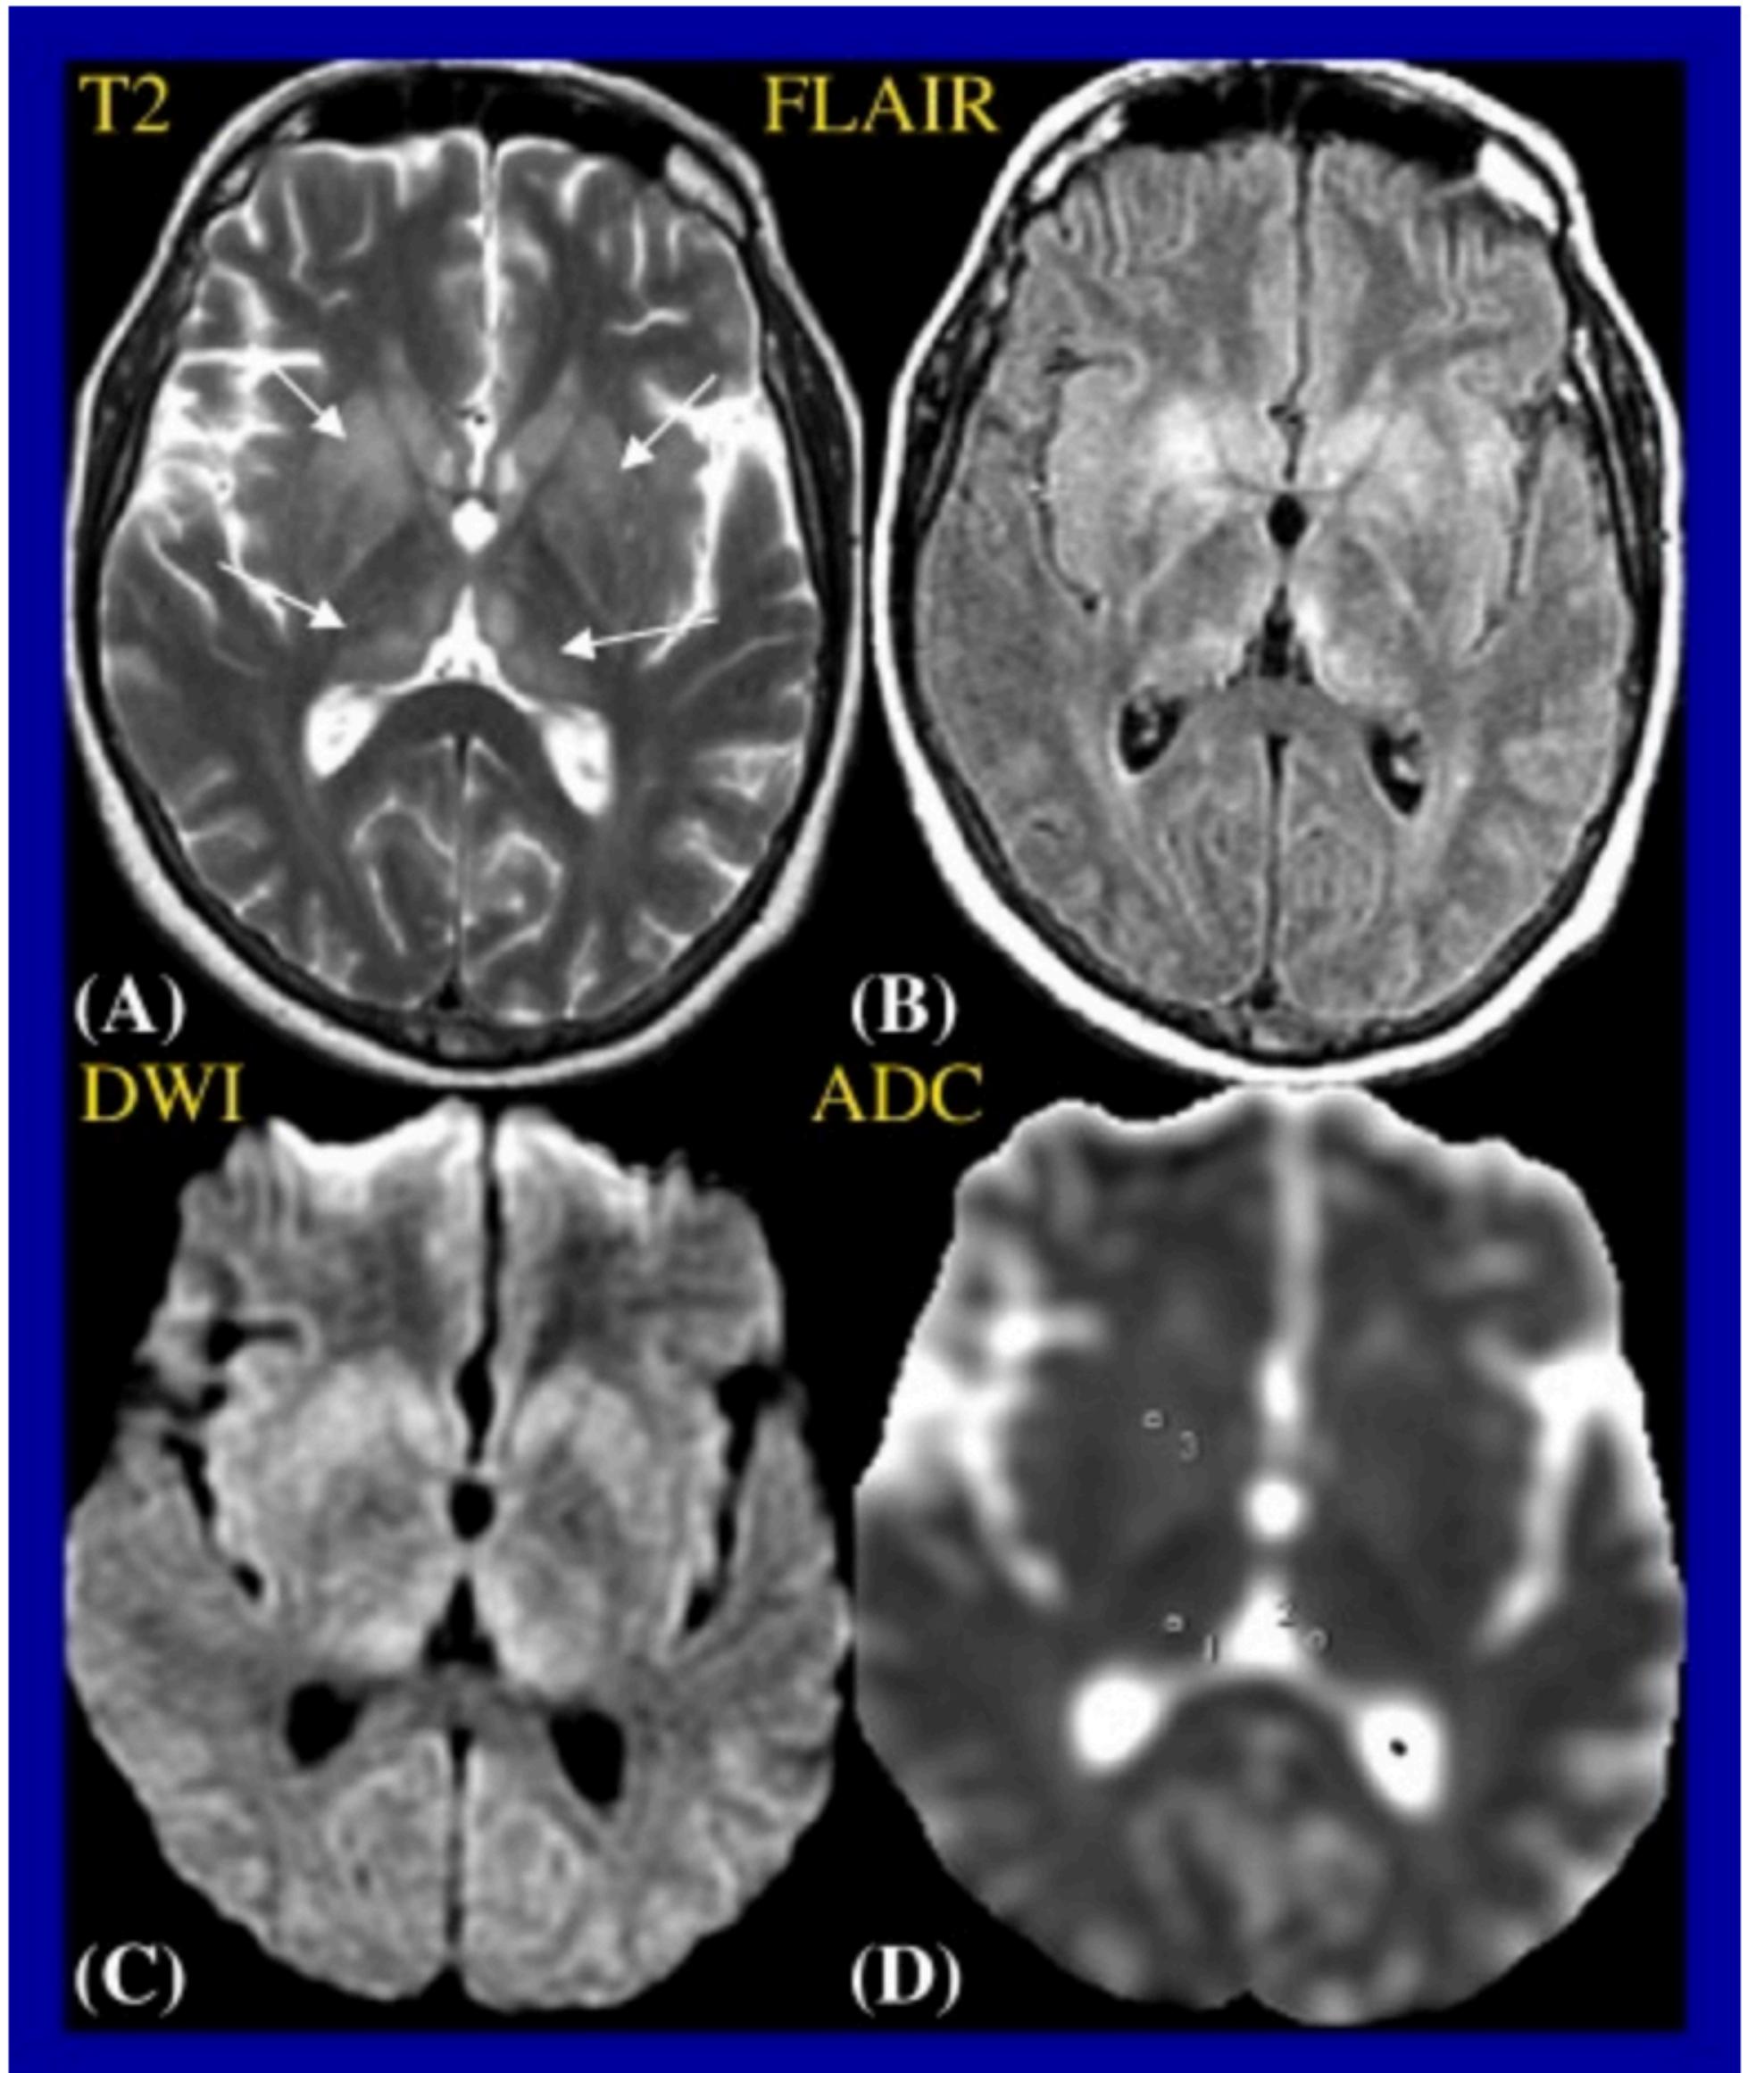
Japanese encephalitis. Axial T2WI (A). FLAIR (B), DWI (C) and ADC map (D) in a JE patient 4 days after clinical presentation shows involvement of bilateral thalamus (arrows) and basal ganglia (arrows). ADC values were computed from cursor locations and later averaged (average ADC 678×10^{-6} mm 2 /s).
